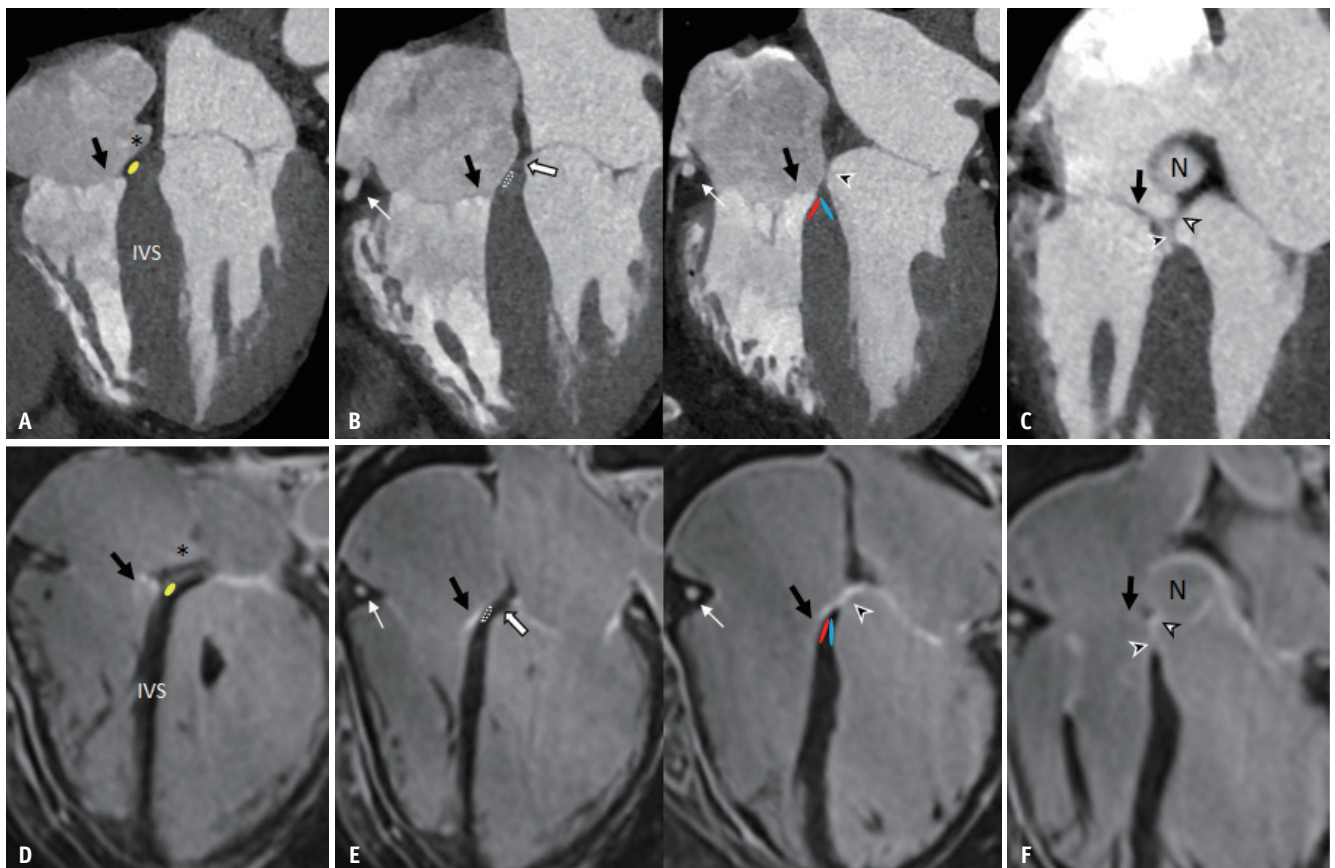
Relationship of the septal leaflet of the TV with the atrioventricular junction and conduction axis on cardiac CT (A-C) and MRI (D-F, contrast-enhanced T1-weighted fast low angle shot inversion recovery sequence).
